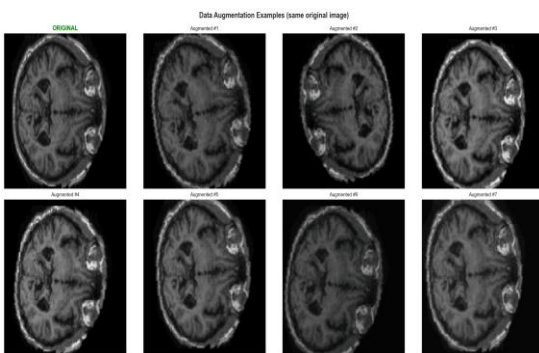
MRI Data Augmentation Examples
